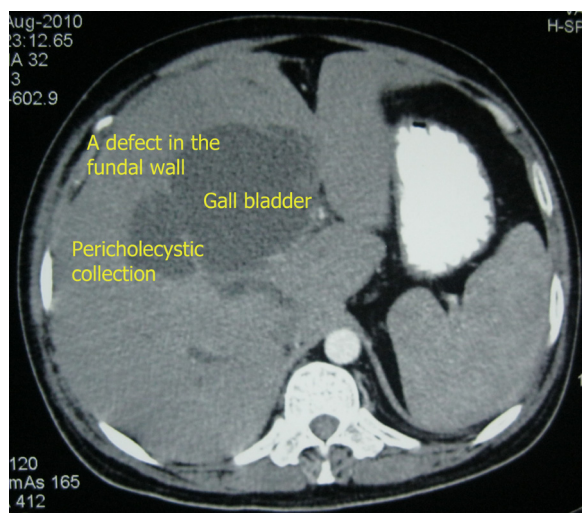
An axial section of an abdominal contrast-enhanced computed tomography showing a defect in the fundus of the gallbladder with a communication to a pericholecystic collection.
